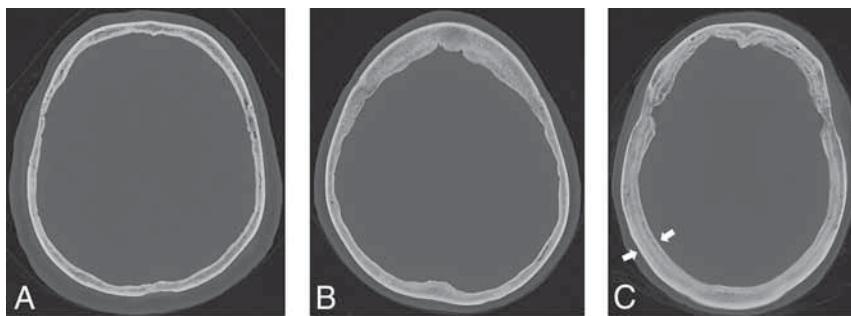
Hyperostosis examples. Normal calvarial thickness (A). Axial bone kernel and bone window CT image with a representative example of normal calvarial thickness. Diffuse calvarial hyperostosis (B). Axial bone kernel and bone window CT image demonstrates diffuse thickening of the calvaria. Layered calvarial hyperostosis (C). Axial bone kernel and bone window CT image demonstrates calvarial thickening with discrete enlargement of the inner and outer tables (white arrows), producing a layered appearance.
